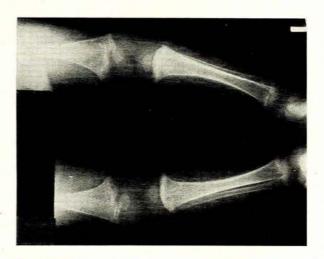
Radiographs of long bones of lower limbs before treatment.
